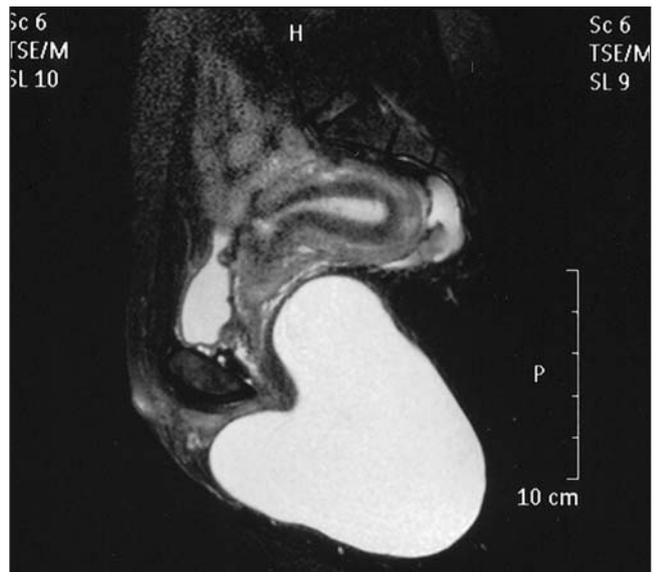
Sagittal T_2 -weighted magnetic resonance image of the pelvis.
